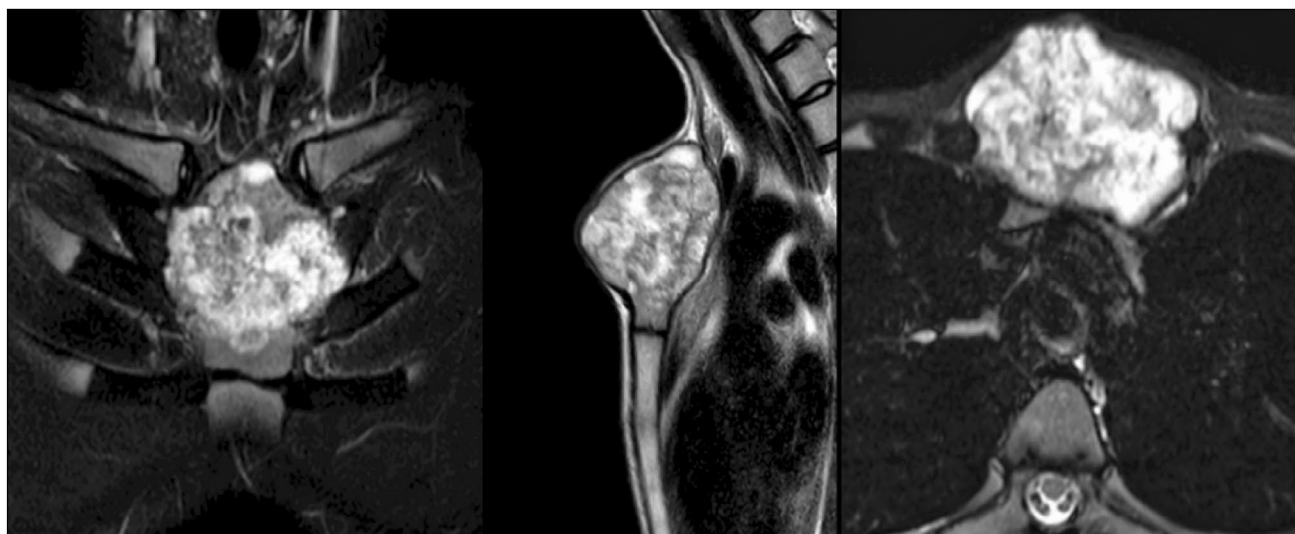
Magnetic resonance image of the manubrium of the patient G.
